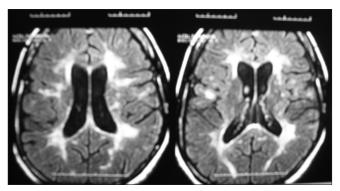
FLAIR-weighted MR imaging shows demyelinating plaques compatible with multiple sclerosis
